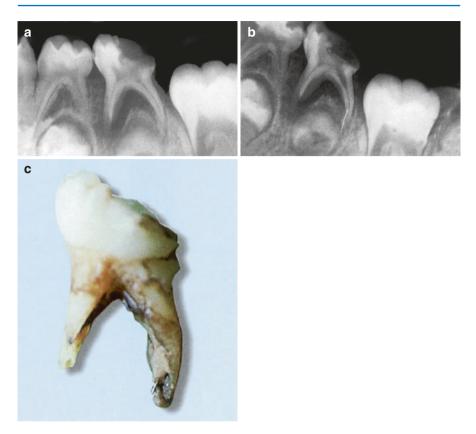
(a) Preoperative radiograph. (b) Radiographic confirmation of the fragment's presence and identification of its location. (c) Extraction of tooth. The tip of the fragment protruding into periapical tissues is discernible (with permission from Lambrianidis 2001)
